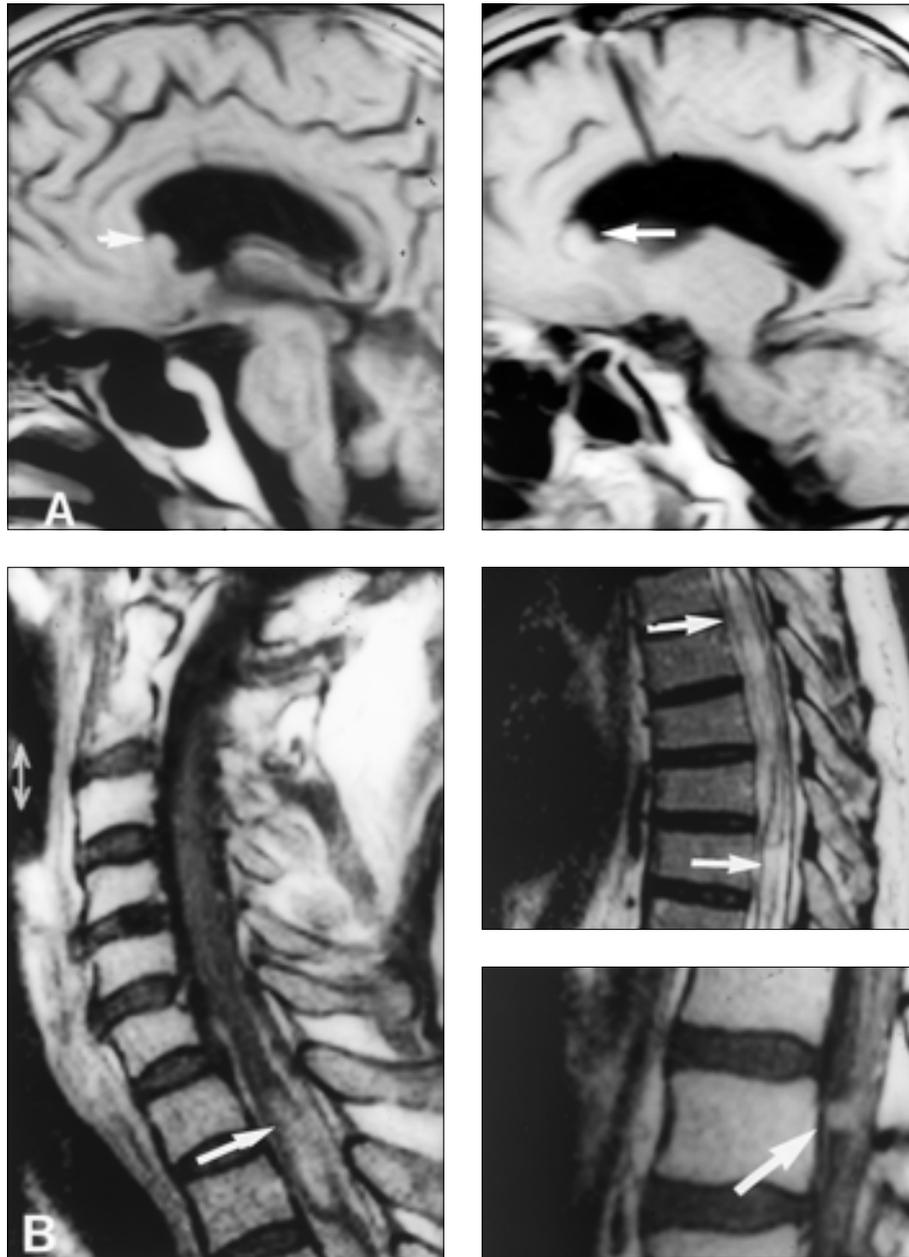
MRI six and a half years after finishing treatment showed two hyperdensity areas near the frontal horn of the right lateral ventricle (A, arrows) and multiple lesions of cervical, thoracic and lumbar spine (B, arrows).
